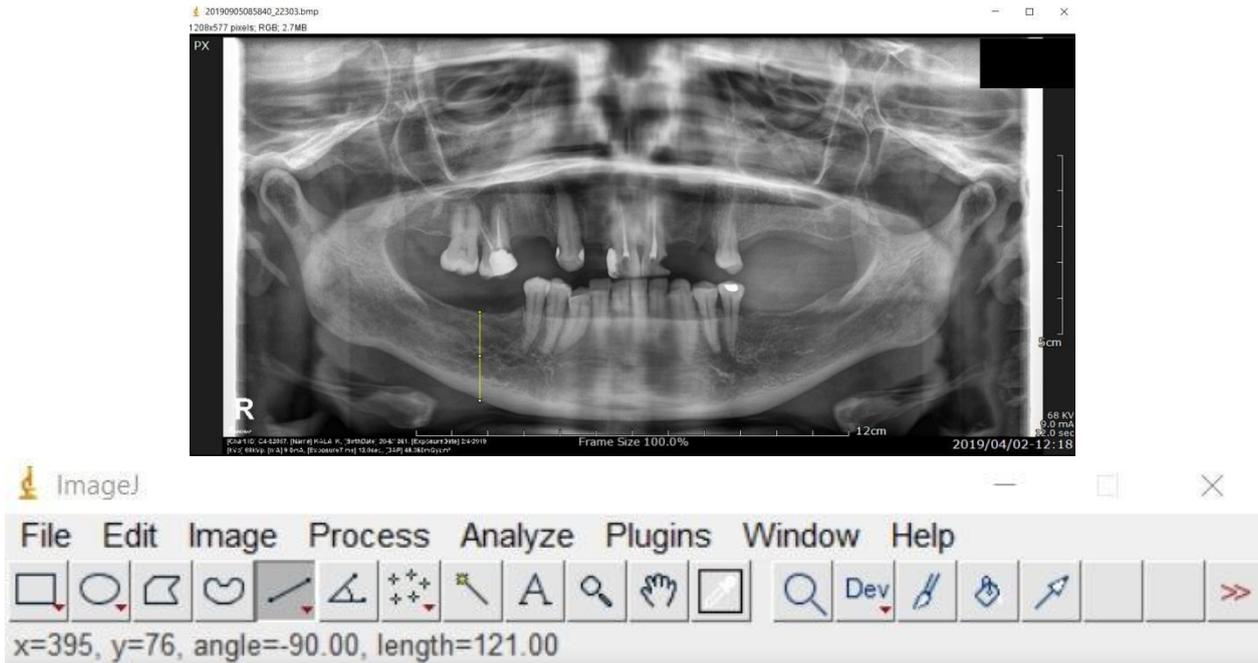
Orthopantomogram being measured in ImageJ software. The bone height was measured from the inferior border of the mandible and the crest of the ridge in edentulous areas; the inferior border of the mandible and the alveolar crest in the dentulous areas. The height was obtained in pixels from the software which was later converted into distance in millimeter (mm).
